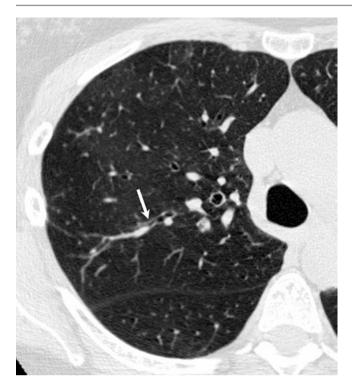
A 56-year-old woman with acute exacerbation of asthma. HRCT shows subtle mosaic attenuation, diffuse centrilobular nodularity, mild bronchial dilatation, and bronchial wall thickening (white arrow)
